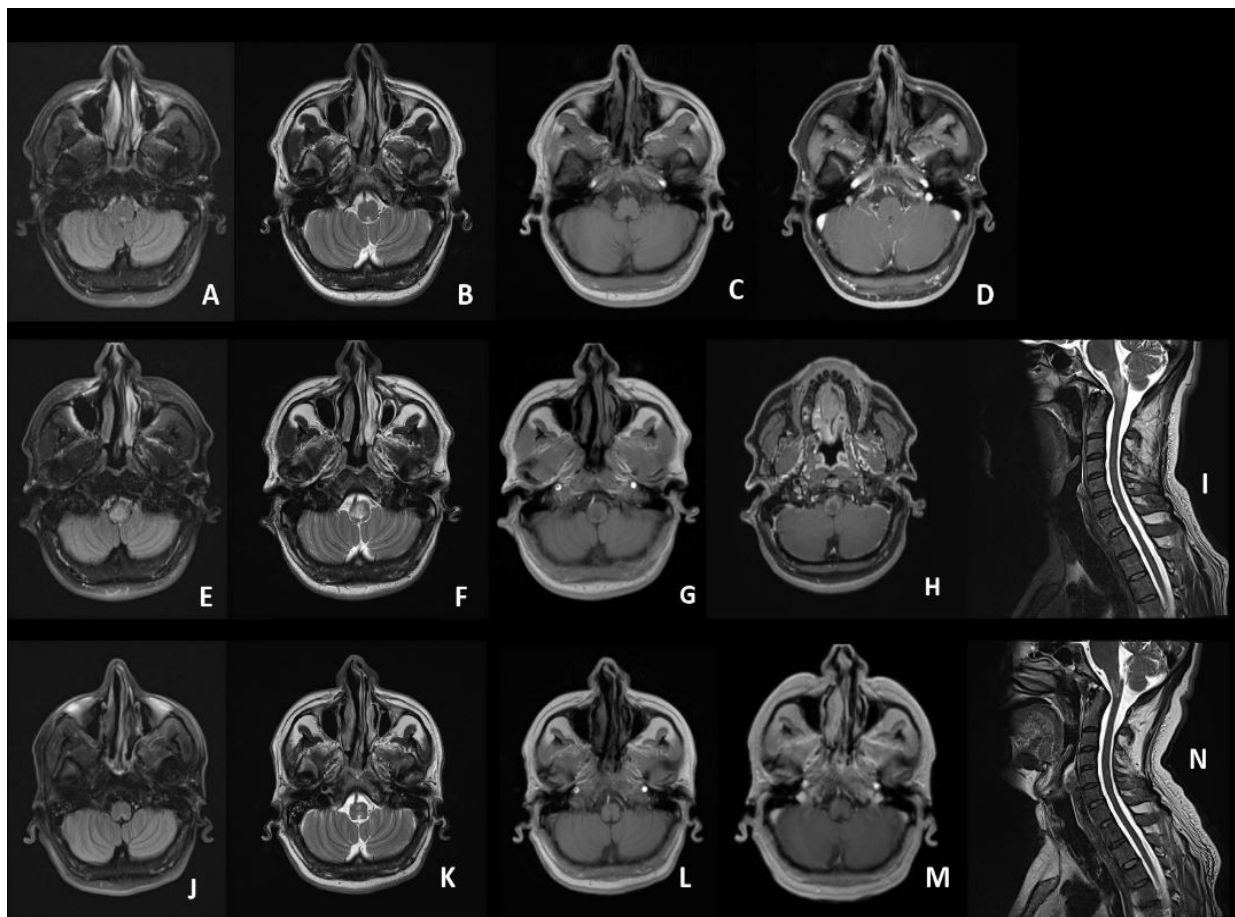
(A,B,C,D) shows subtle enhancement around area postrema, although it was not reported. (E, F, G, H, I) shows T2 and FLAIR hyper-intense signals in the medulla and pons with mild post contrast enhancement. (J, K, L, M, N) showing interval subtle regression in size and signal intensities of the lesion in medulla and the cervico-medullary junction with no significant post contrast enhancement.
